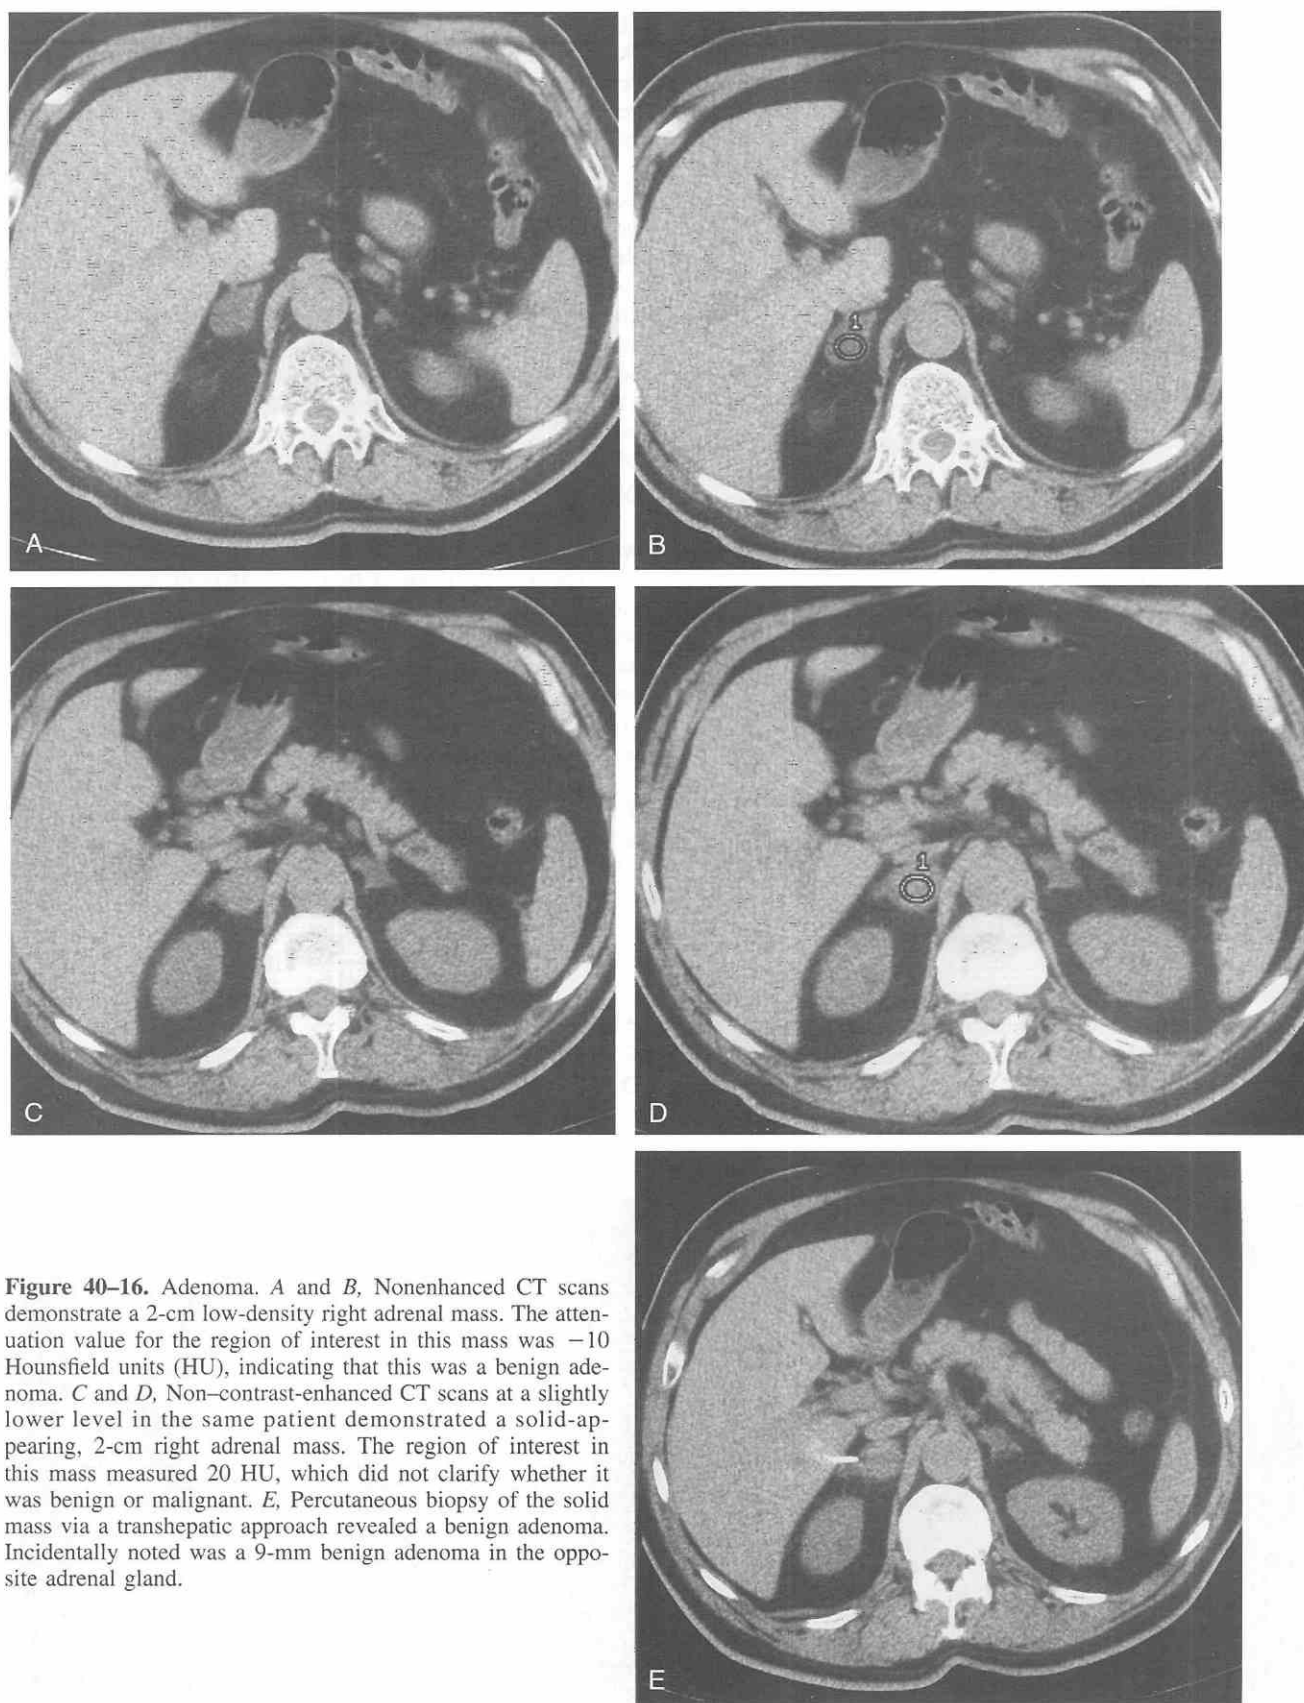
Adenoma. *A* and *B*, Nonenhanced CT scans demonstrate a 2-cm low-density right adrenal mass. The attenuation value for the region of interest in this mass was -10 Hounsfield units (HU), indicating that this was a benign adenoma. *C* and *D*, Non-contrast-enhanced CT scans at a slightly lower level in the same patient demonstrated a solid-appearing, 2-cm right adrenal mass. The region of interest in this mass measured 20 HU, which did not clarify whether it was benign or malignant. *E*, Percutaneous biopsy of the solid mass via a transhepatic approach revealed a benign adenoma. Incidentally noted was a 9-mm benign adenoma in the opposite adrenal gland.
